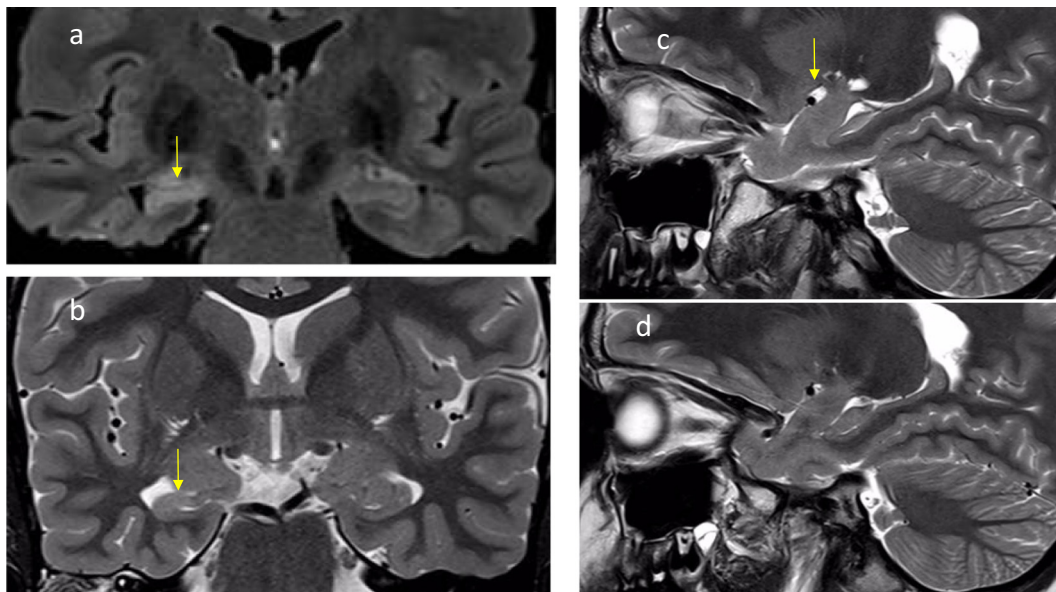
a–d: Mesial temporal lobe Epilepsy with hippocampal sclerosis, amygdala and temporal lobe volume reduction in a 10-year-old boy. Coronal FLAIR (a), and T2 w (b) images through hippocampus (b), sagittal T2 w slice through right (c) and left (d) hippocampus and amygdala. Marked gliosis of cornu ammonis (a) with atrophy of pes hippocampi and loss of interdigitations (b). Generalized atrophy of temporal lobe volume as evidenced by position of sylvian fissure and amygdala volume loss indicated by width of choroid fissure are additional findings present in 50% and 20% of patients with mesial temporal lobe sclerosis respectively.
